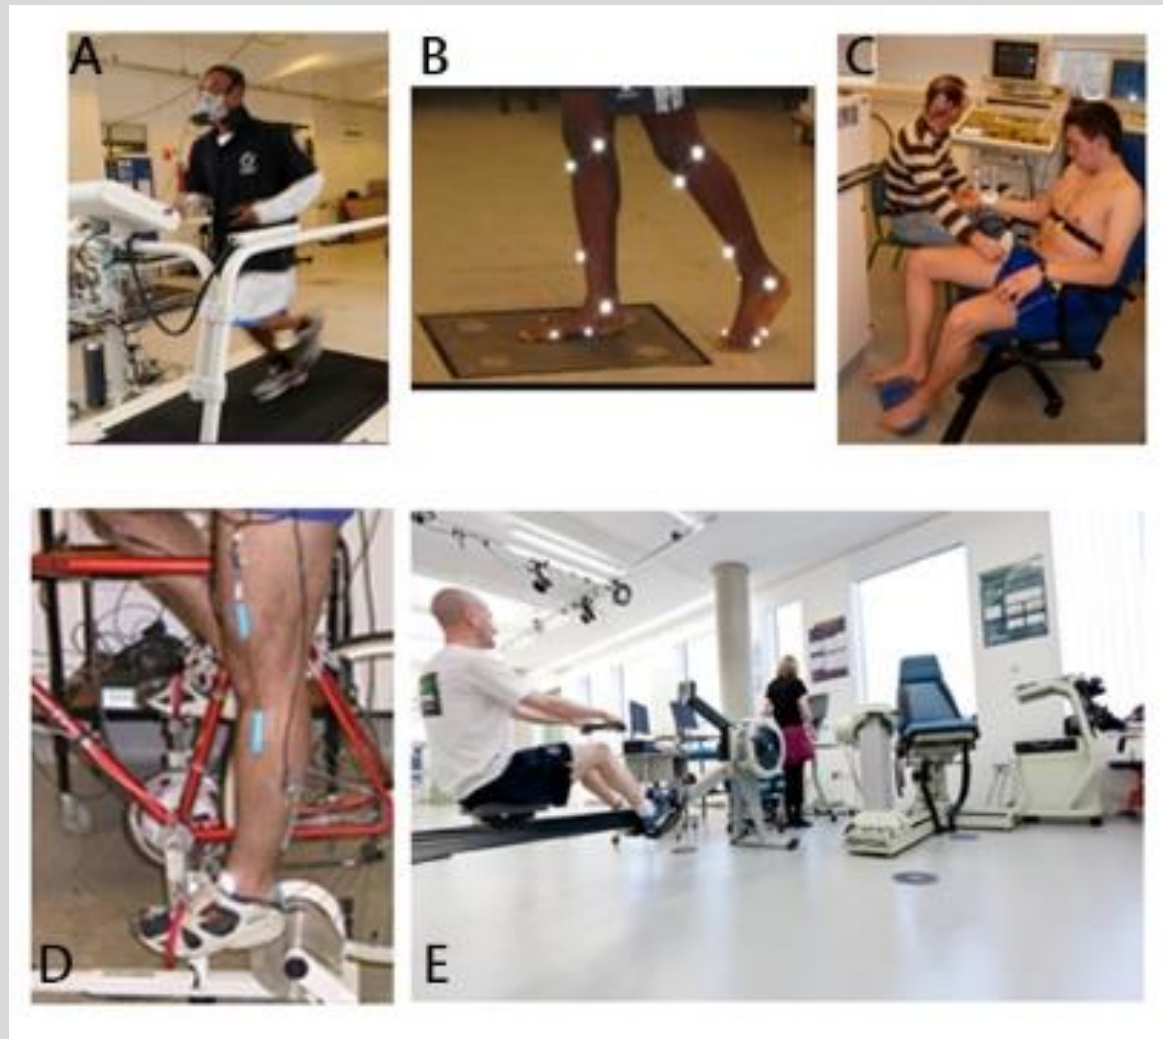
Physiological factors most often measured in Sport and Exercise Science to assess health and fitness are respiratory capacity and energy expenditure during activities such as treadmill running, VO₂max test (A), mobility and flexibility using reflective markers (B), blood flow changes in peripheral arteries using Doppler Ultrasound (C) and neuromuscular function using electromyography and electrogoniometry (D), and strength, endurance and power during exercise modalities such as rowing (E). Body composition and diet as well as sleep patterns can also be critical factors in sports performance, health status and quality of lives. Scientific databases offer abundant literature detailing the best testing protocols and equipment, data analysis and interpretation approaches.
